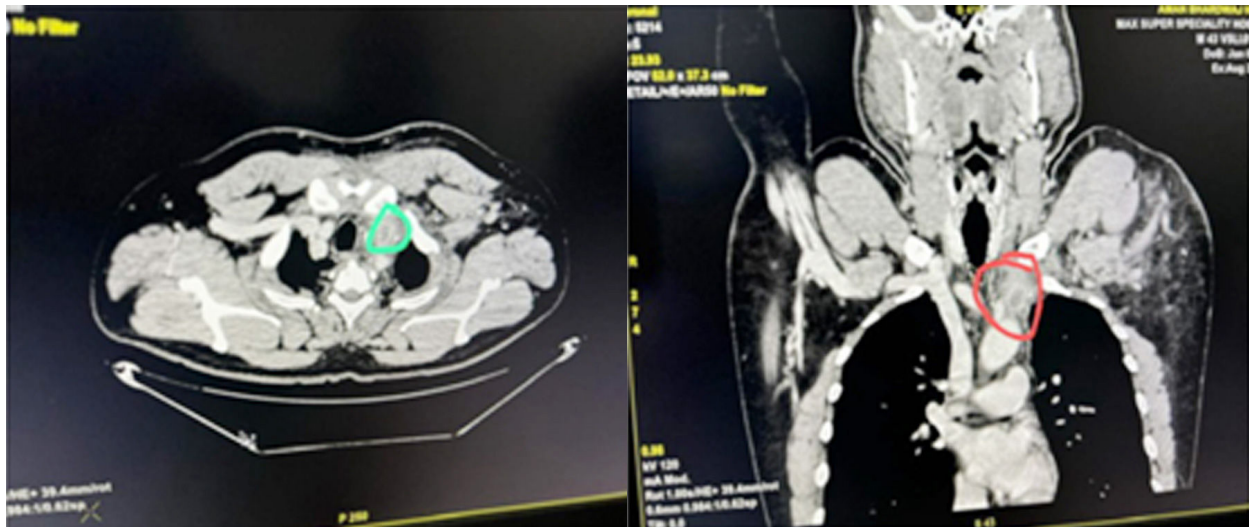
CT Venogram Scan, Marked Areas Are Locating Thrombus in Left IJV
